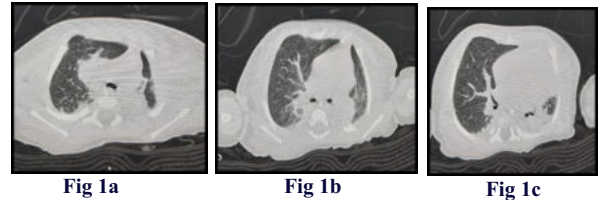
CT images reveal---collapse consolidation of left lower lobe with typical patchy and confluent areas of consolidation, surrounding ground glass opacities (GGO) in both upper lobe (Fig 1a), lingual lobe (Fig 1b) and right & left lower lobe (Fig 1c).
